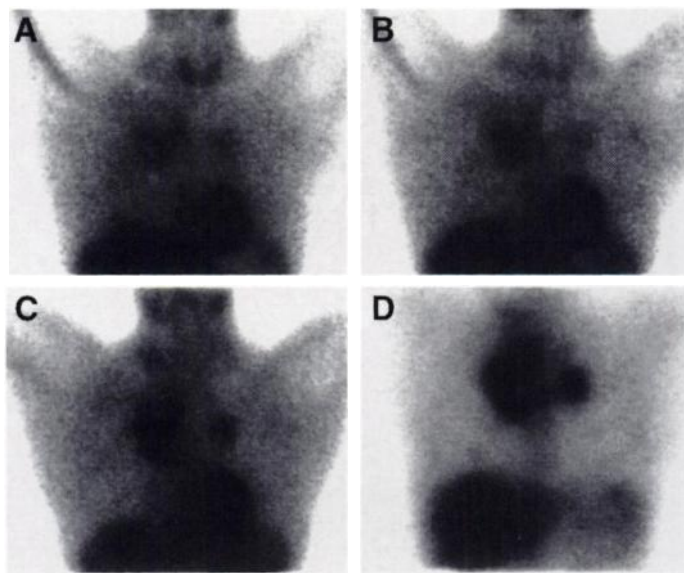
High-grade immunoblastic lymphoma in a patient with a mediastinal mass on CT and palpable inguinal nodes. Notice the mixed pattern of superior ^{201}Tl detection of inguinal nodes but superior mediastinal detection with ^{67}Ga .
